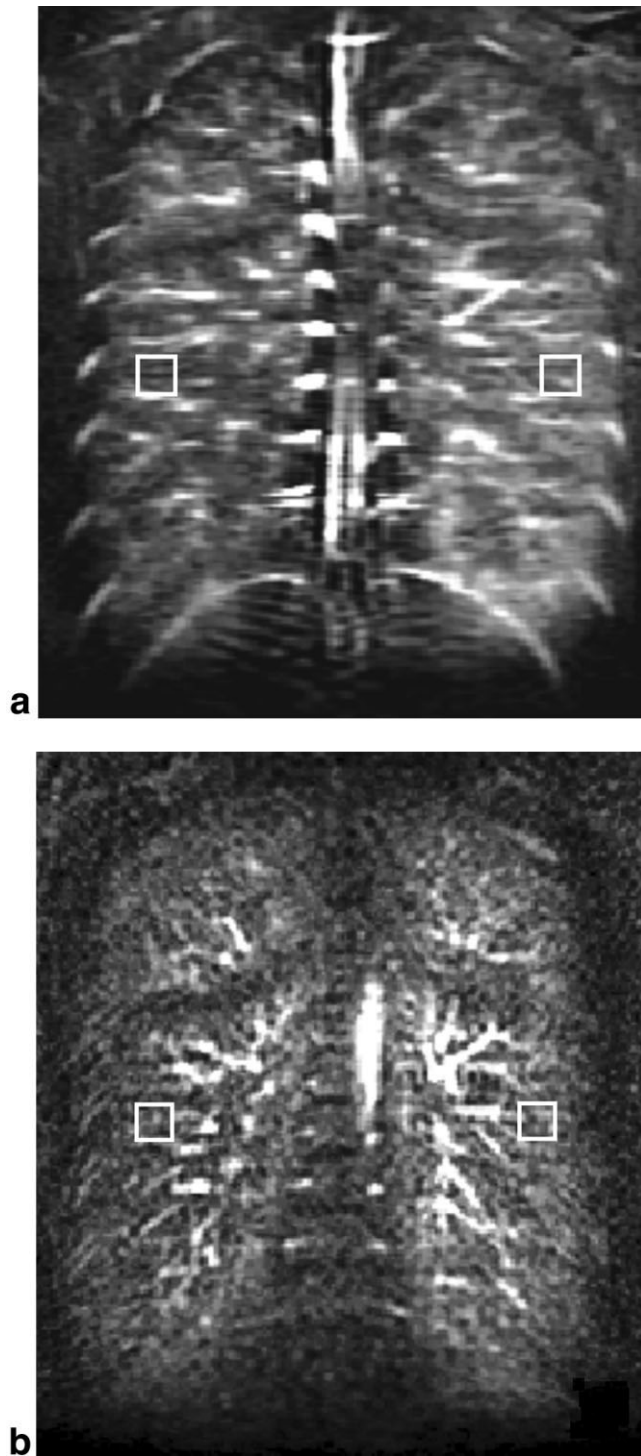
Coronal rPBF maps of the posterior slice from a 23-year-old male subject obtained using (a) the FAIR (rPBF derived from a subtraction of the tagged and control images) and (b) the CE-MRI techniques (rPBF derived using central volume principle from the γ -fitted first-pass Gd-bolus transit), respectively. With regions of large vessels excluded, the exemplified rectangular regions-of-interest (white boxes) yielded $R_{\text{FAIR}} = 0.84$ and $R_{\text{CE-MRI}} = 0.85$, suggesting that FAIR and CE-MRI provide consistent information in pulmonary perfusion.
